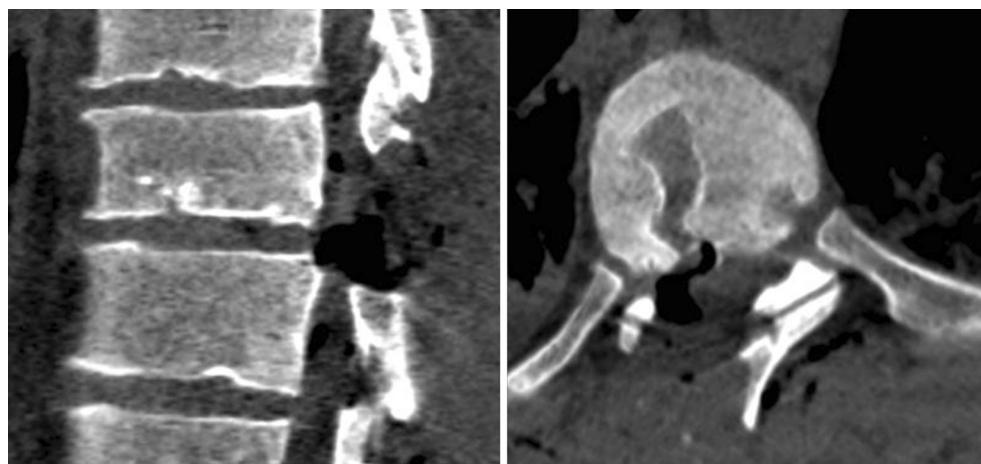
Case 1 postoperative CT scan showing removal of the disc herniation
